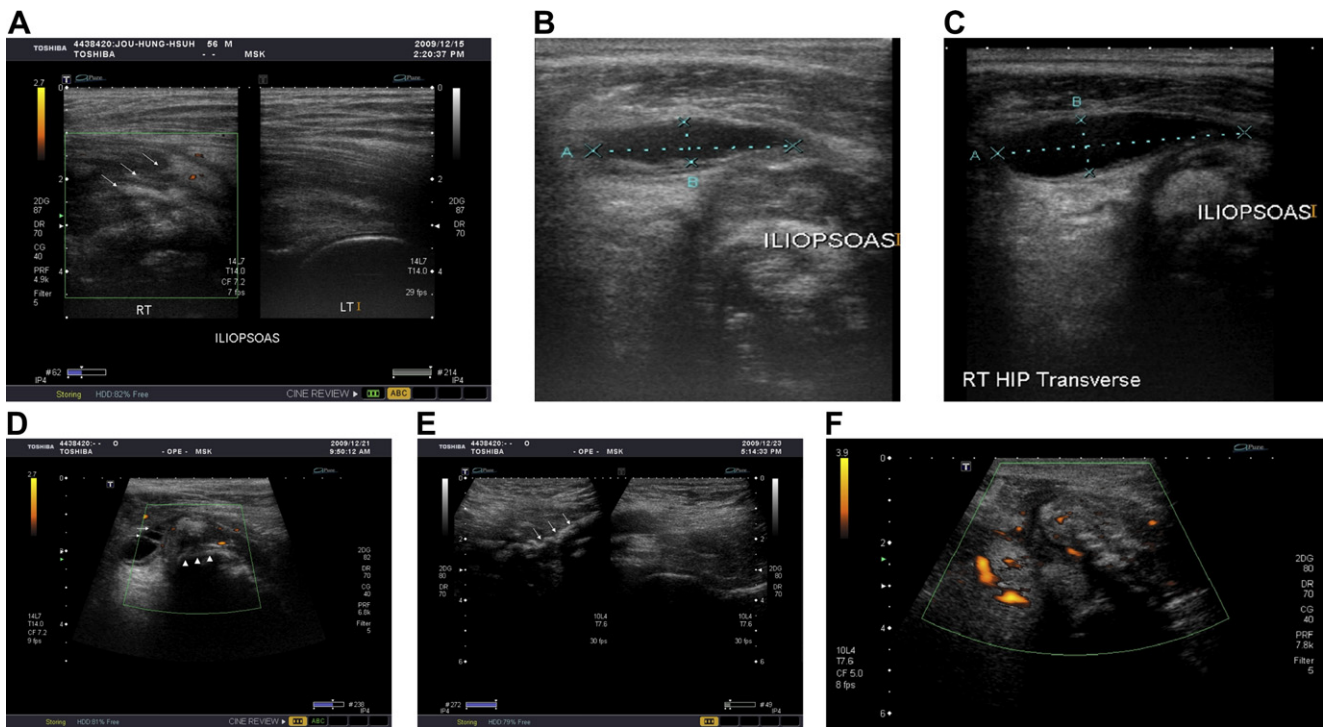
Serial ultrasonography pictures. (A) left picture: 1 week after symptom onset, longitudinal ultrasonography imaging showed disarrayed muscle fibers (arrows) of right iliopsoas with perifocal swelling and increased vascularity. Right picture: Normal muscle texture on the sound side; (B) a 21.2 × 5.6 mm hypoechoic mass without internal vascularity between the right sartorius and iliopsoas muscles seen 1 week after initial symptoms (transverse view); (C) 9 days after symptom onset, an enlarged hypoechoic mass (30.5 × 7.3 mm) located between the iliopsoas and gracilis muscles was seen (transverse view); (D) 13 days after initial symptoms, a septa formation (arrows) within the mass and the appearance of hyperechoic lesions (arrowheads) with acoustic shadows around the iliopsoas muscle were shown (transverse view); (E) left picture: on Day 15, blurred muscle echotexture and multiple hyperechoic lesions (arrows) with strong acoustic shadow obscuring the underlying bone cortex. Right picture: normal muscle echotexture (longitudinal view); (F) marked increase of vascularity 15 days after symptom onset (transverse view).
